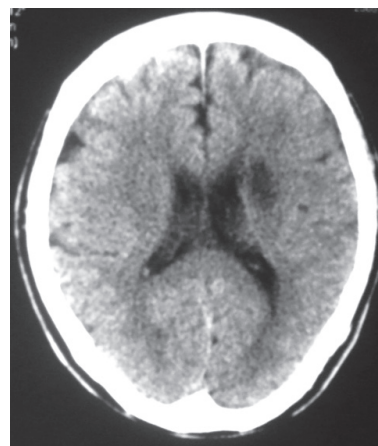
Computed tomography showing a stroke smaller than 3 cm, affecting the insula
